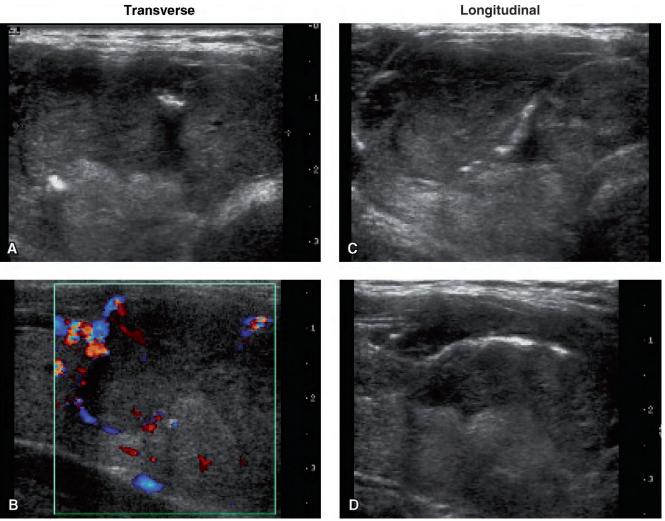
Ultrasound of follicular thyroid carcinoma in the right lobe. A, Transverse, 31 x 37 mm. B, Color Doppler, transverse. C and D, Longitudinal.
